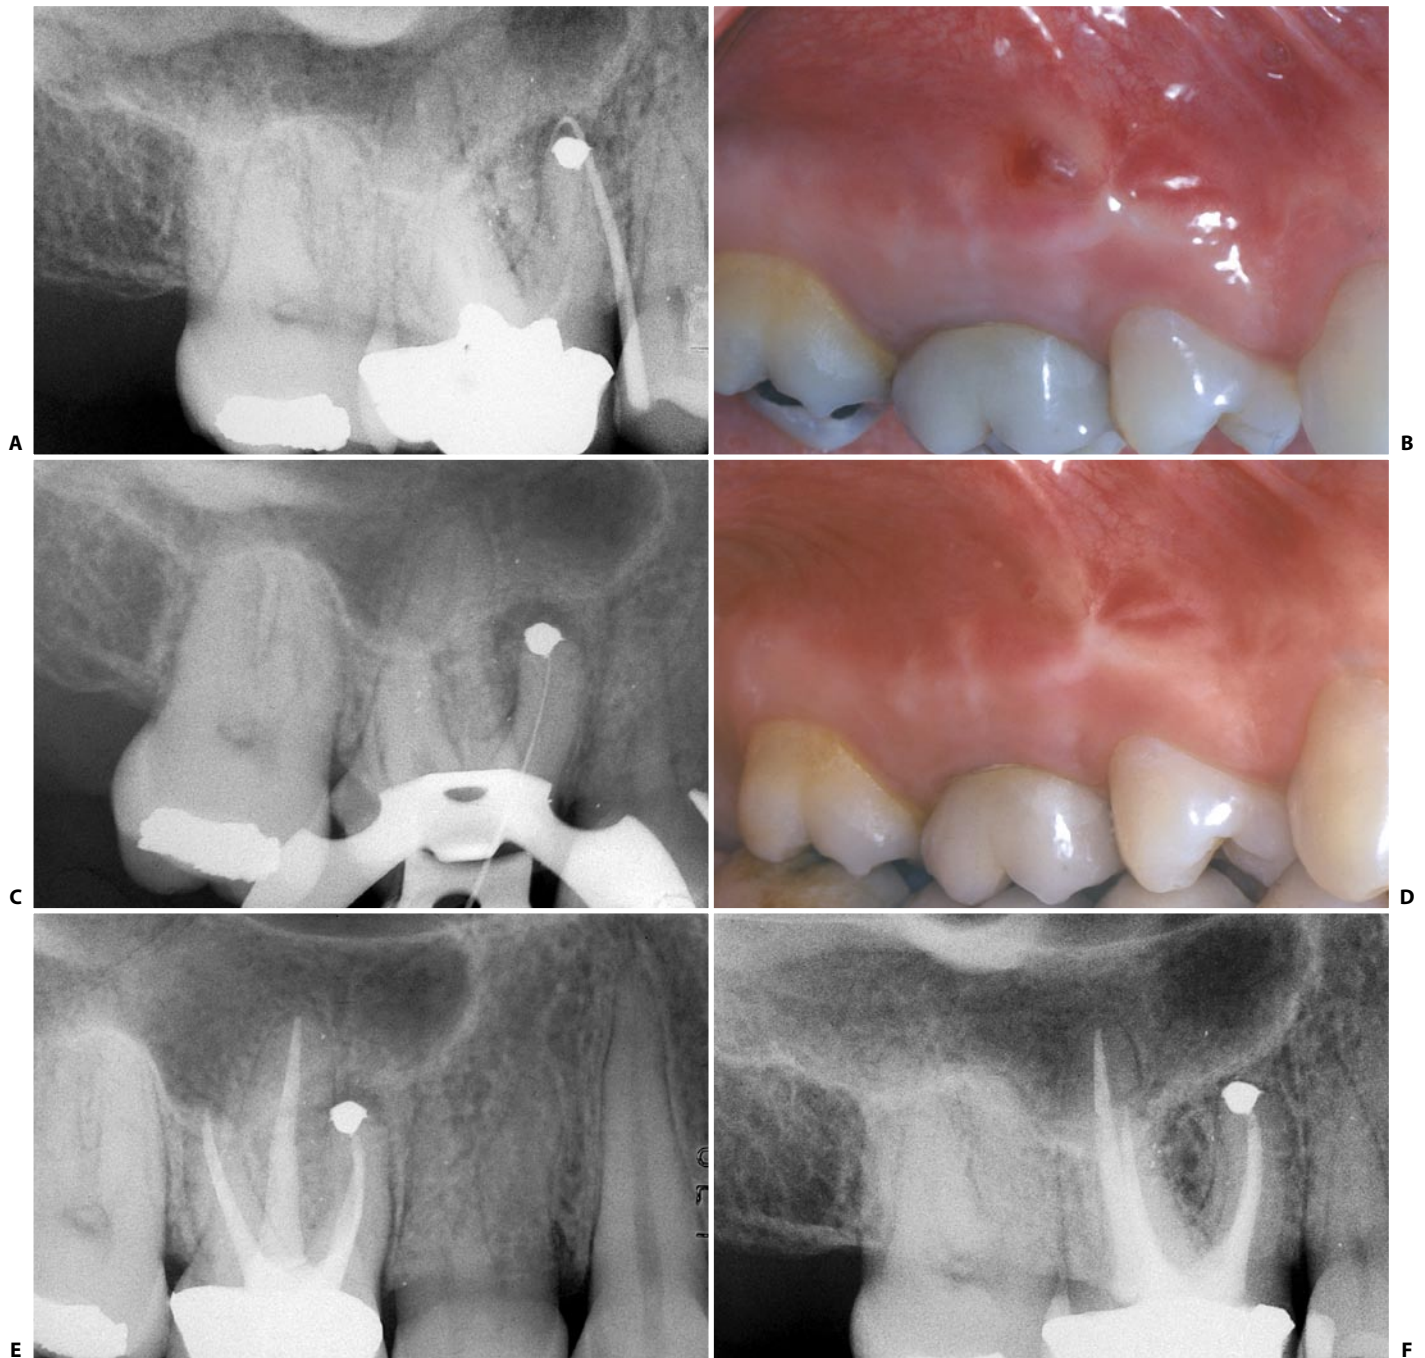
Non surgical retreatment of a surgical failure: the obturation of the mesiobuccal and mesiopalatal canals were made using the thermoplastic gutta-percha: the previous amalgam retrofilling was a perfect apical stop, and there was no risk of pushing filling material into the periapical tissues A. Preoperative radiograph of the upper right first molar: the gutta-percha cone is indicating the presence of a fistulous sinus tract. B. Clinical aspect of the fistula. C. Intraoperative radiograph. D. one week after cleaning and shaping the root canals, particularly MB1 and MB2, the fistula healed completely. E. Postoperative radiograph. F. Two year recall.
